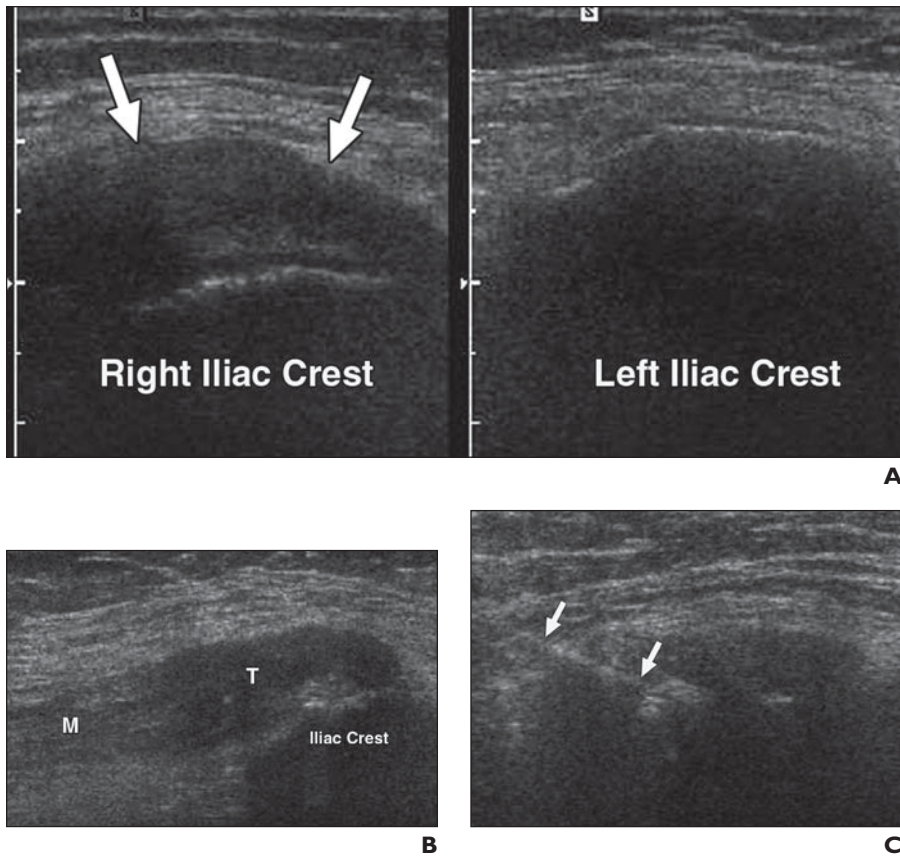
46-year-old woman with 2 years of severe, progressively increasing right “hip” pain. During that time she had undergone two hip MRI examinations and one lumbosacral spine MRI examination, all of which failed to detect cause of pain. In retrospect, none of the MRI examinations included actual source of pain in their field of view.
